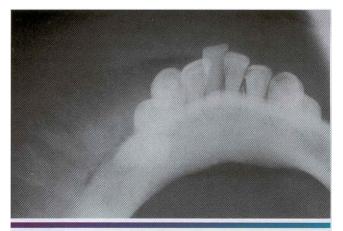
• Osteosarcoma. Occlusal radiograph demonstrating prominent exophytic tumor bone production on the buccal surface of the mandible. resulting in the "sunburst" pattern. (Courte sy of Dr. I ewis Gilbert.)
